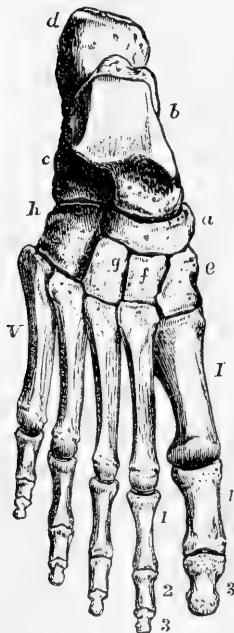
RIGHT FOOT, VIEWED FROM ABOVE, SHOWING ITS DORSAL ASPECT. (A. T.)  $\frac{1}{2}$
